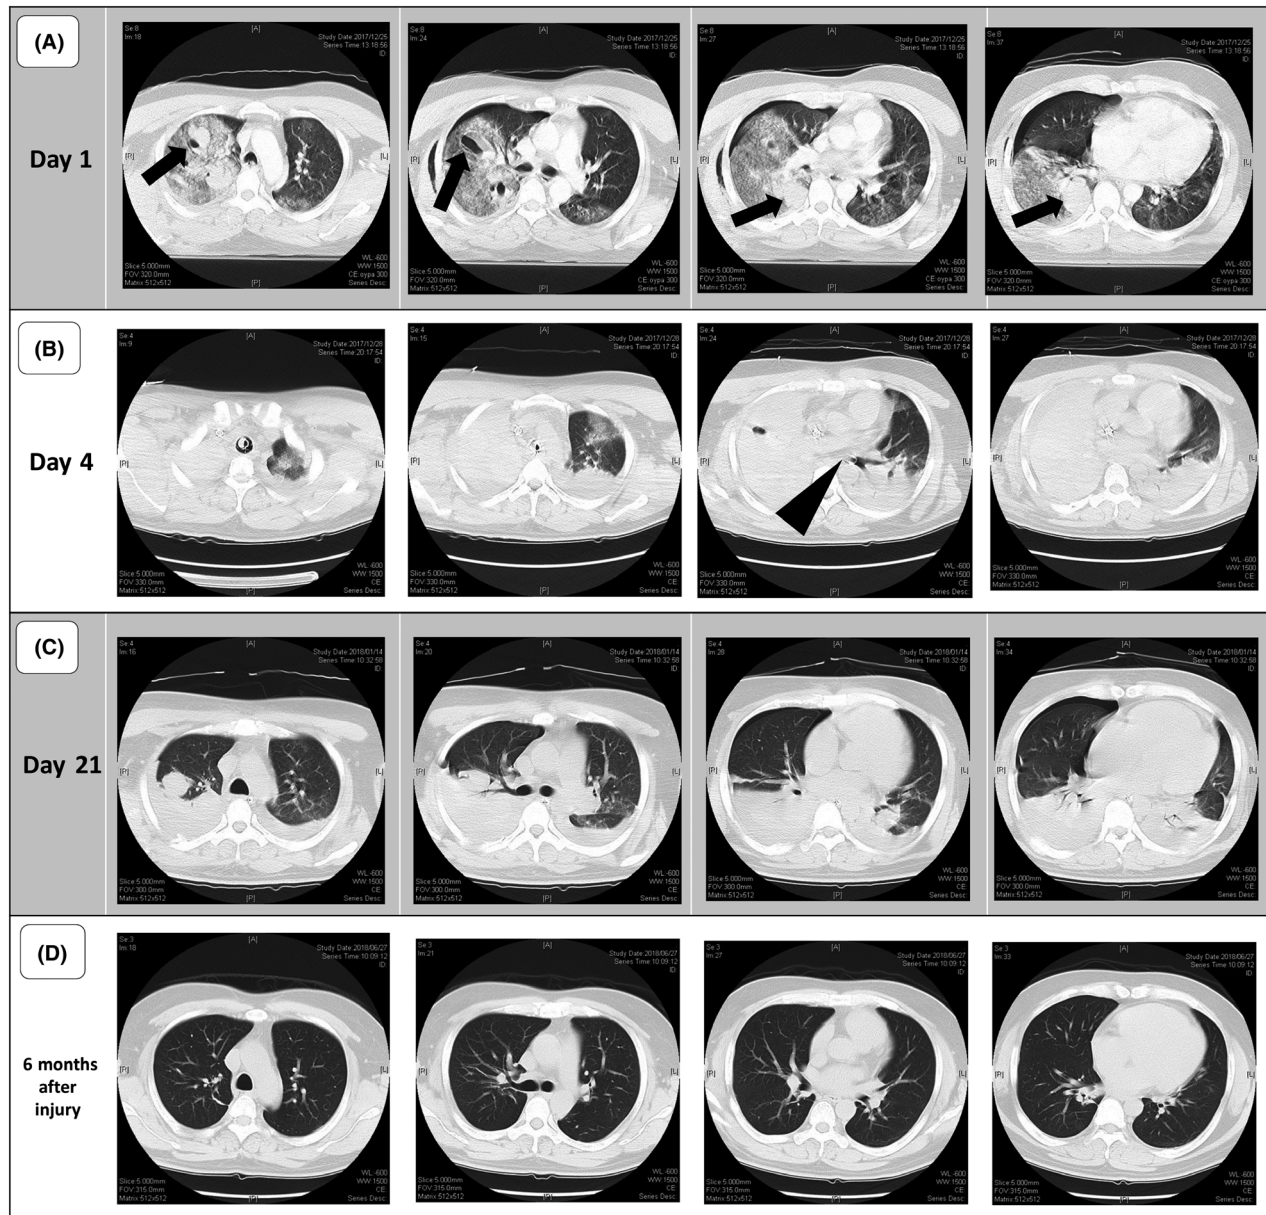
Contrast-enhanced computed tomography scan (CE-CT) of a 34-year-old man on day 1 (A), day 4 (B), day 21 (C), and 6 months (D) after a traumatic lung injury. A, Multiple large pneumatoceles (arrows) and hemopneumothorax on the right. B, CE-CT several hours after the initiation of veno-venous extracorporeal membrane oxygenation (V-V ECMO). Entire right lung and right lumen of the double-lumen tube (DLT) is filled with blood due to hemoptysis. Tip of the left DLT is in an appropriate position (arrowhead). C, CE-CT after removal of V-V ECMO. Pneumatoceles remain but pulmonary contusion has healed. D, Confirmed complete resolution of the pneumatoceles at outpatient follow-up 6 months after the injury.
